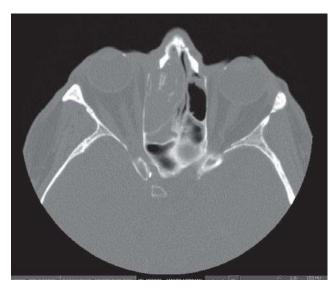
Axial CT scans showing an inverted papilloma filling the right nasal cavity and eroding the medial wall of the orbit
